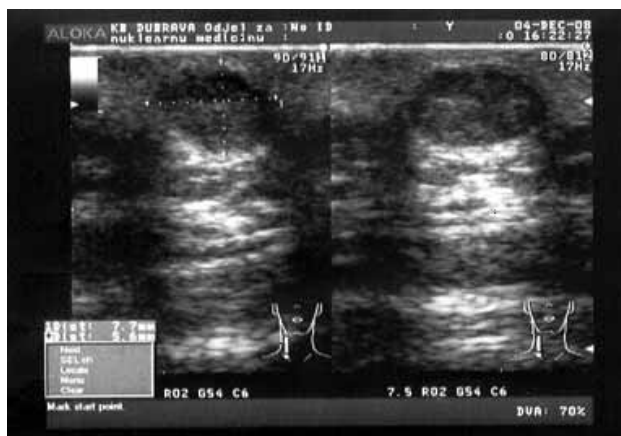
Ultrasonography of small subcutaneous mass measuring 8 mm in diameter.
